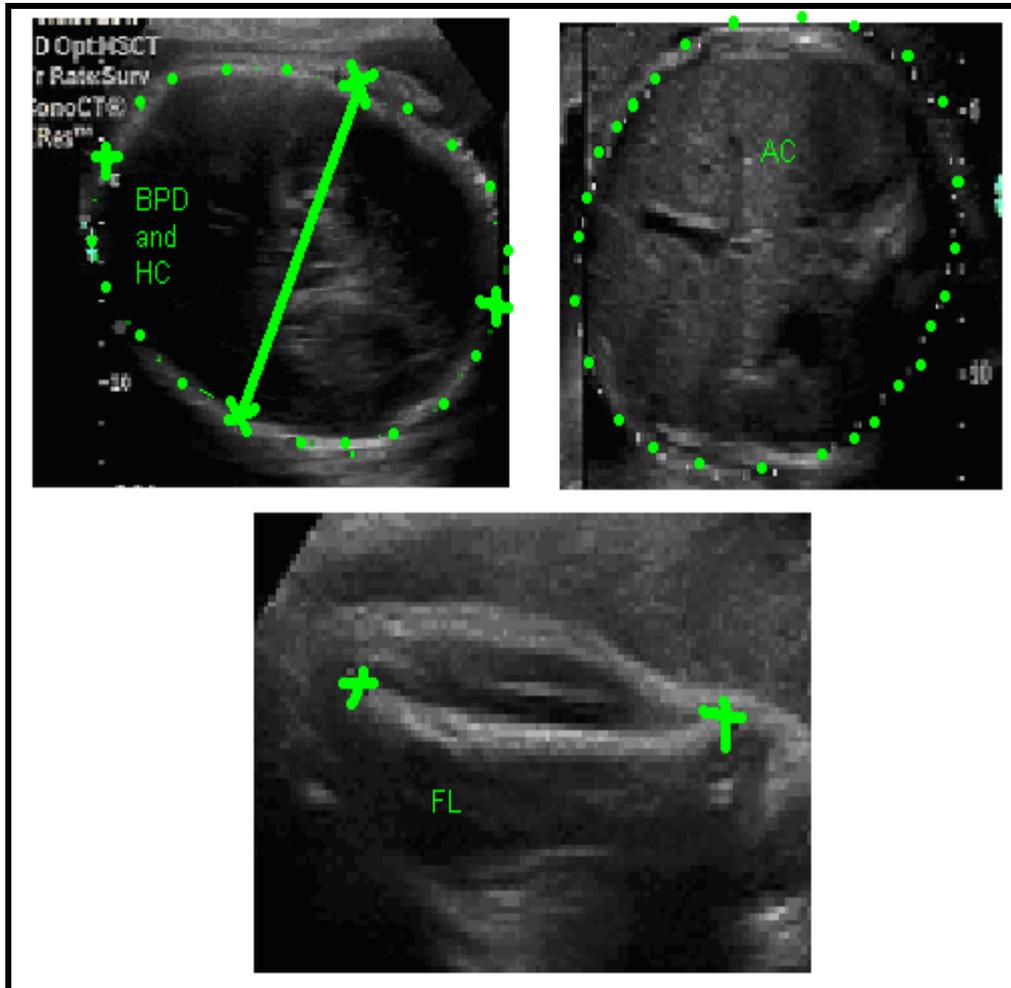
Sonographic planes for biometric measurements.
